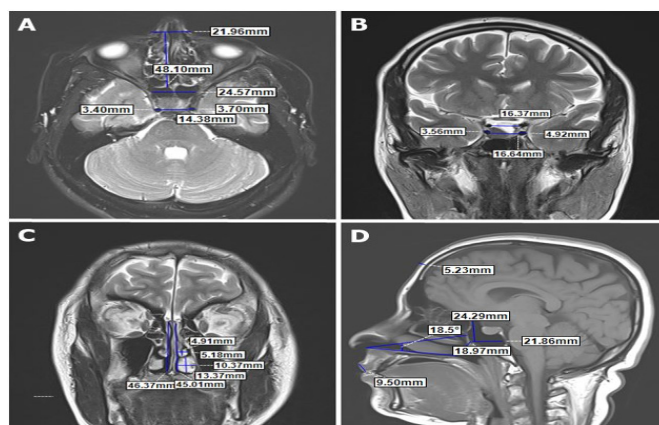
Anatomical dimensions measured in preoperative axial, coronal, and sagittal MRI. A: Axial T2 MRI; Clinoid segment intercarotid distance (14.38 mm), right carotid canal width (3.4 mm), left carotid canal width (3.7 mm), sphenoid sinus width (24.57 mm), pyriform aperture width (21.96 mm), distance from pyriform aperture to anterior face of sphenoid (48.10 mm). B: Coronal T2 MRI; Cavernous segment intercarotid distance (16.64 mm), clinoid segment intercarotid distance (16.37 mm), right carotid canal width (3.56 mm), left carotid canal width (4.92 mm). C: Coronal T2 MRI; Nasal cavity height right (46.37 mm)-left (45.1 mm), inferior concha width (10.37 mm)-height (13.37 mm), middle concha width (5.18 mm)-height (4.91 mm), and D: Sagittal T1 MRI; Sphenoid sinus anterior posterior width (21.86 mm), sphenoid sinus height (24.29 mm), choanal height (18.97 mm), angle from anterior nasal floor to anteroinferior face of sphenoid sinus (18.5°), lip thickness (9.5 mm), frontal skin thickness (5.23 mm)
